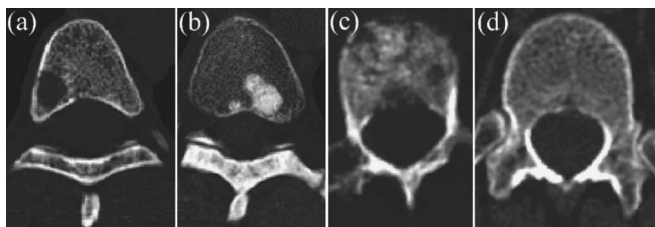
Clinical CT slices of vertebral bodies representing different cases the algorithm will have to successfully segment: (a) a vertebrae with a distinct focal lytic lesion in the lower left vertebral body, (b) a vertebrae with a distinct focal blastic lesion in the lower right vertebral body, (c) a vertebrae with diffuse mixed involvement of the entire vertebral body, and (d) a healthy vertebral body.
